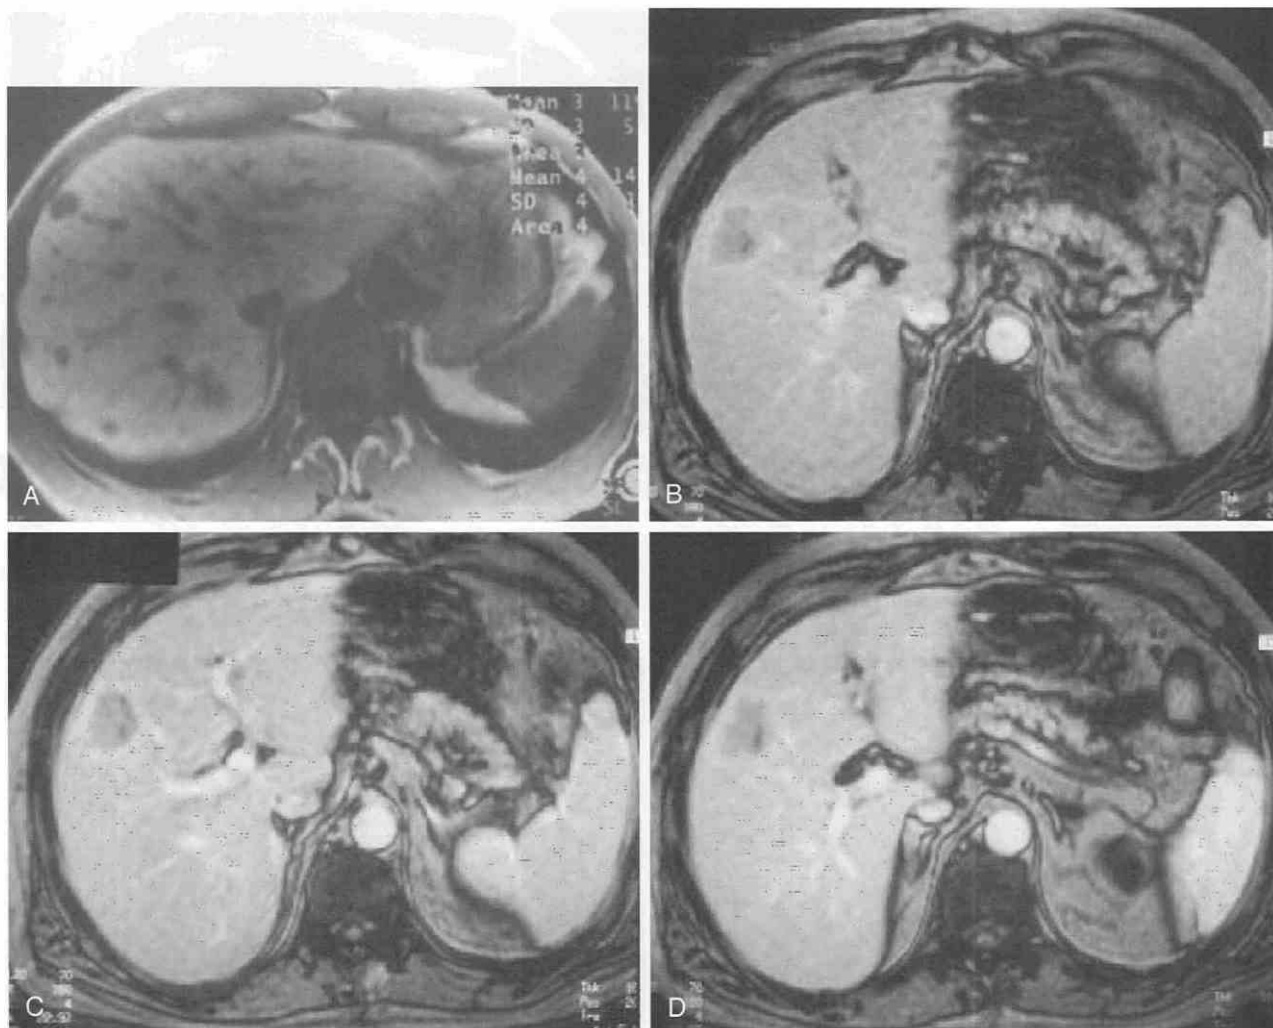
Liver metastases. *A*, Unenhanced T1-weighted image demonstrates a lesion in the right hepatic lobe. *B*, After administration of gadolinium (Gd-DTPA), the lesion shows rim enhancement. *C*, As the liver parenchyma enhances, the rim of tumoral enhancement becomes less apparent. *D*, On portal venous phase imaging, the rim of enhancement is no longer able to be identified.
